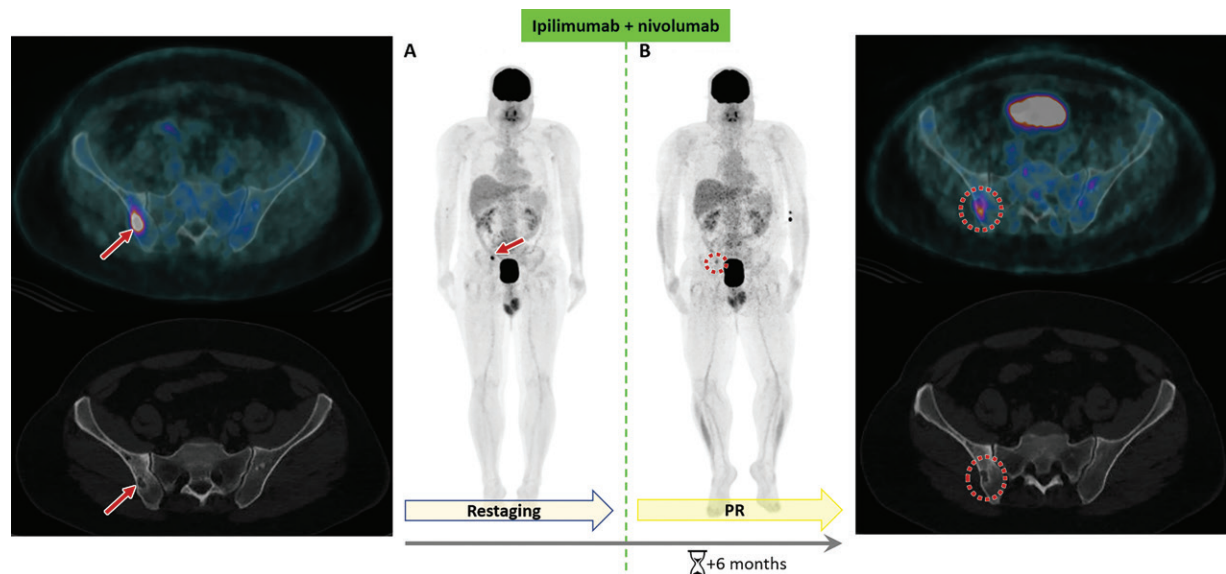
Bone lesion with a partial response (PR) to immunotherapy in a 50-year-old man with metastatic melanoma of unknown primary site previously treated with lumbar spine radiosurgery and whole-brain radiation therapy. He underwent FDG PET/CT for restaging. A, FDG PET image (right) and axial PET/CT (top left) and CT (bottom left) images show a metastatic bone lesion in the right ilium (arrow). Ipilimumab therapy was started, followed by nivolumab therapy; 6 months later, FDG PET/CT was performed for restaging and response assessment. B, FDG PET image (left) and axial PET/CT (top right) and CT (bottom right) images show a partial metabolic response (red dotted circle).
